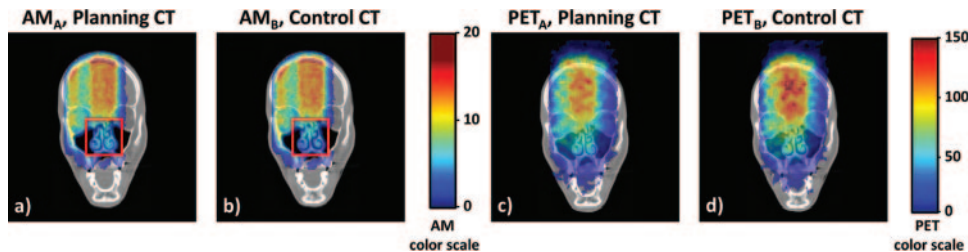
(a), (b): slice of the planning and control CT with overlaid the corresponding AMs. In the red box, the morphological change (very small, just a tiny empty of the sinus) is highlighted. (c), (d): the same slice but now with the corresponding IB-PET images. The activity present outside the patient is an example of the limitations present in IB-PET data.
